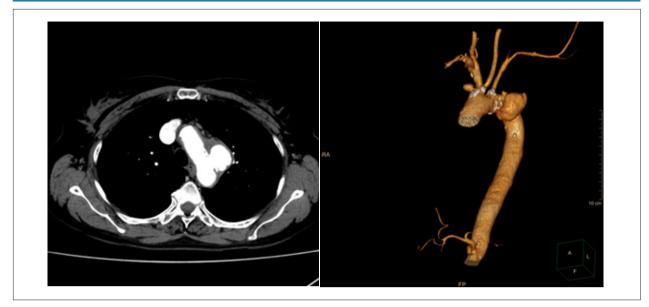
Computed tomography angiography. A) Saccular aneurysmatic dilation after the emergence of the left subclavian, partially thrombosed, measuring 4.2 cm in length and 2.4 x 2.8 cm in the largest diameters. B) Image obtained after 3D reconstruction.
